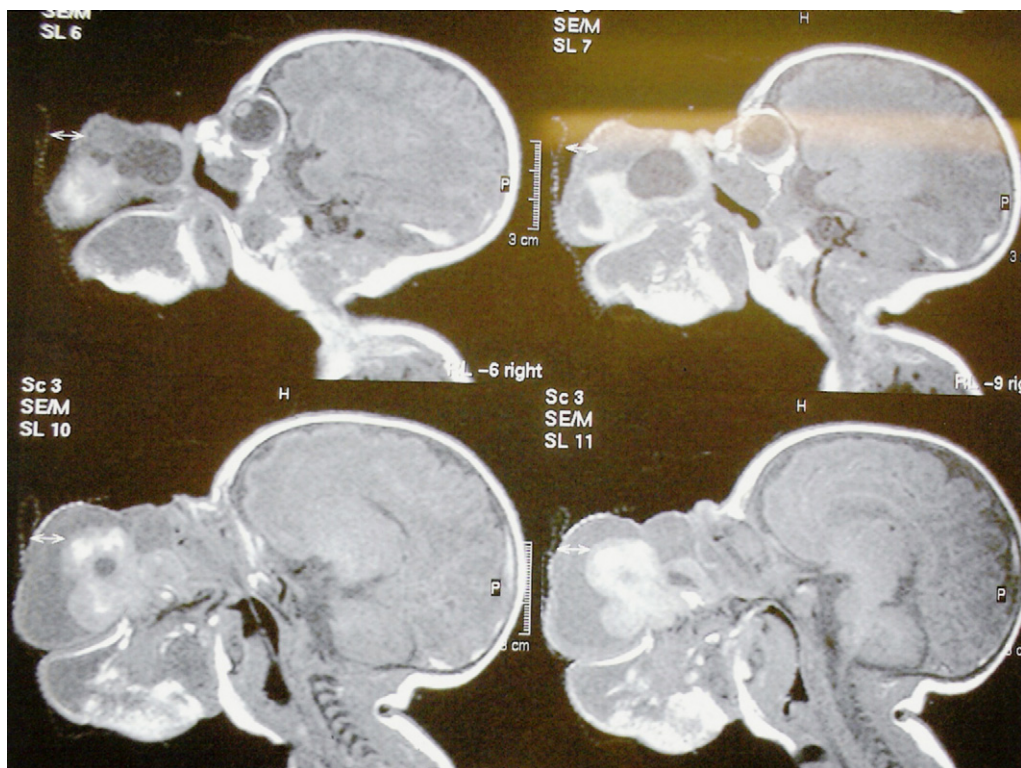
Sagittal CT view: Pedicled mass from the hard palate, with areas of high and low attenuation. No intracranial extension is apparent.
